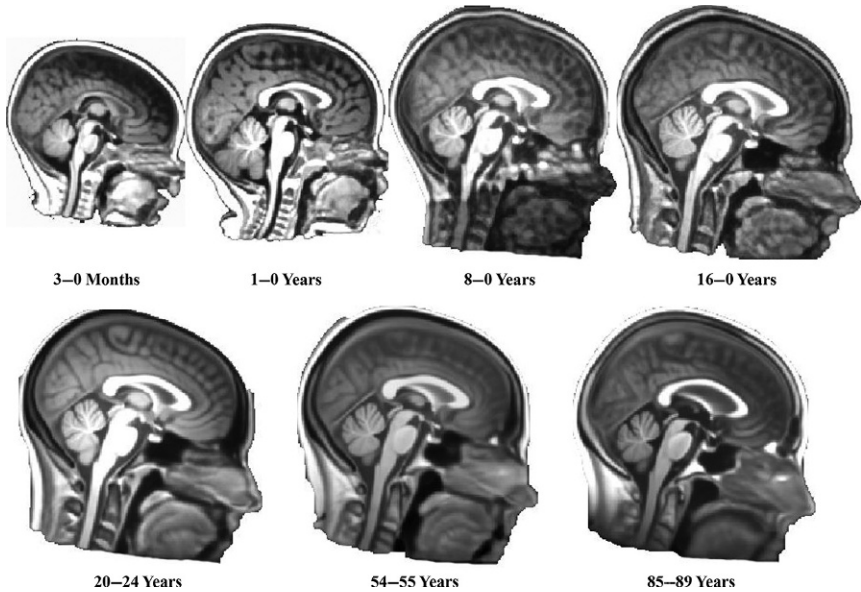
Whole-head average MRI templates for selected ages from the Neurodevelopmental MRI Database. This is a midsagittal slice, and heads are oriented approximately with the MNI template orientation. The size of the figures is proportional to the size of the average template for that age.
